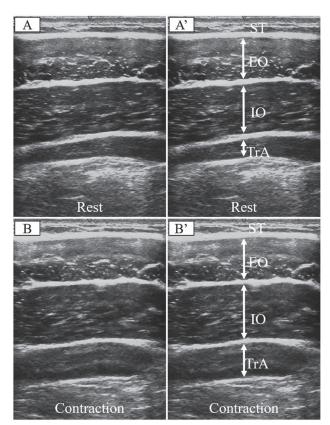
Ultrasonographic image of the lateral abdominal muscles. Figure A is an ultrasonographic image during relaxation, and Figure B is an image during contraction. ST, soft tissue; EO, external oblique muscle; IO, internal oblique muscle; TrA, transverse abdominal muscle
